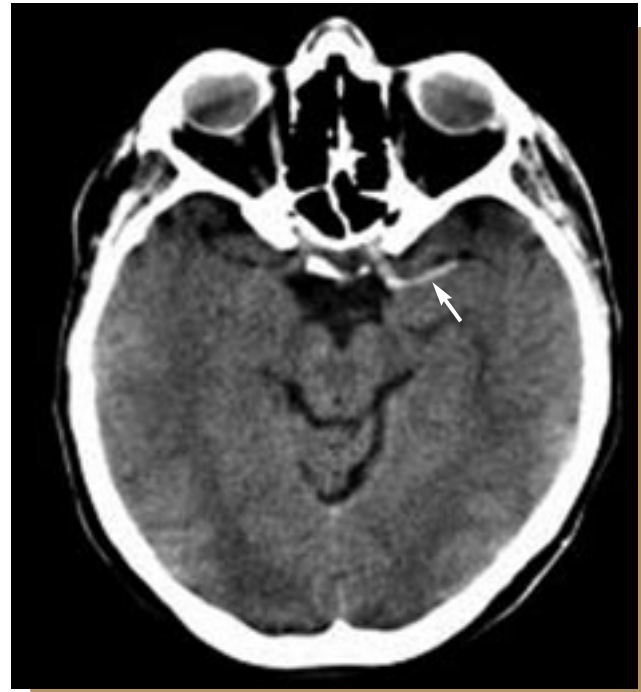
A CT image through the level of the internal carotid artery terminus showed a curvilinear density just lateral to the left anterior clinoid process (arrow). This finding represents embolism within the left internal carotid artery.
